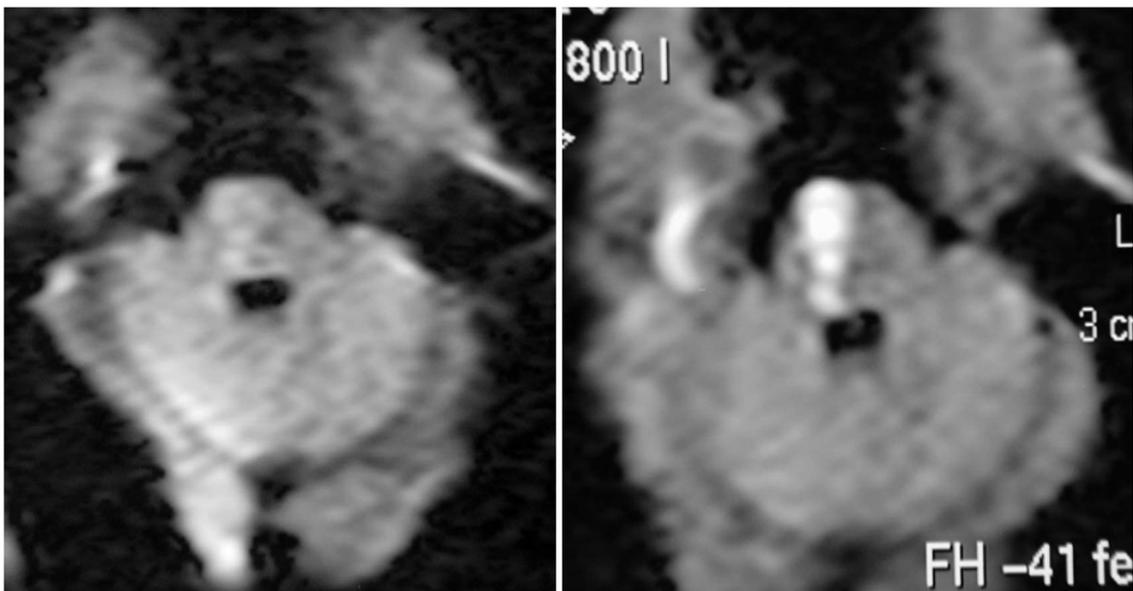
DWI (right) is more sensitive than T2 FLAIR.
